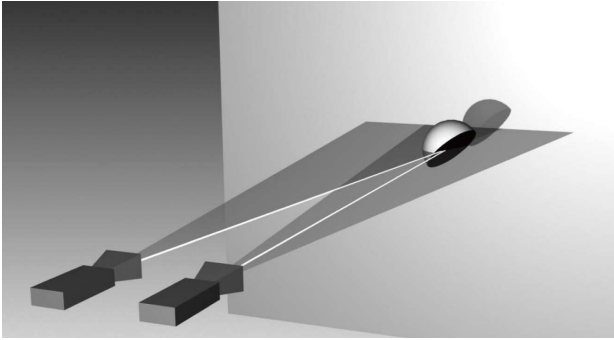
The scheme of model of anteroposterior pelvis view (X-ray source on the left) and anteroposterior hip view (X-ray source on the right) for acetabular cup of left hip.
